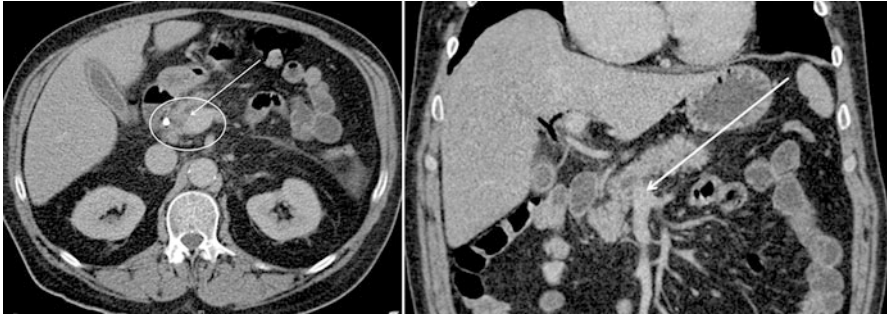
BR-PDAC of the pancreatic neck. Contrast-enhanced CT scan (porto-venous phase, axial left, and coronary reformatting right side). Tumor (*white circle*) with contact to the porto-venous confluence (*white arrow*)
